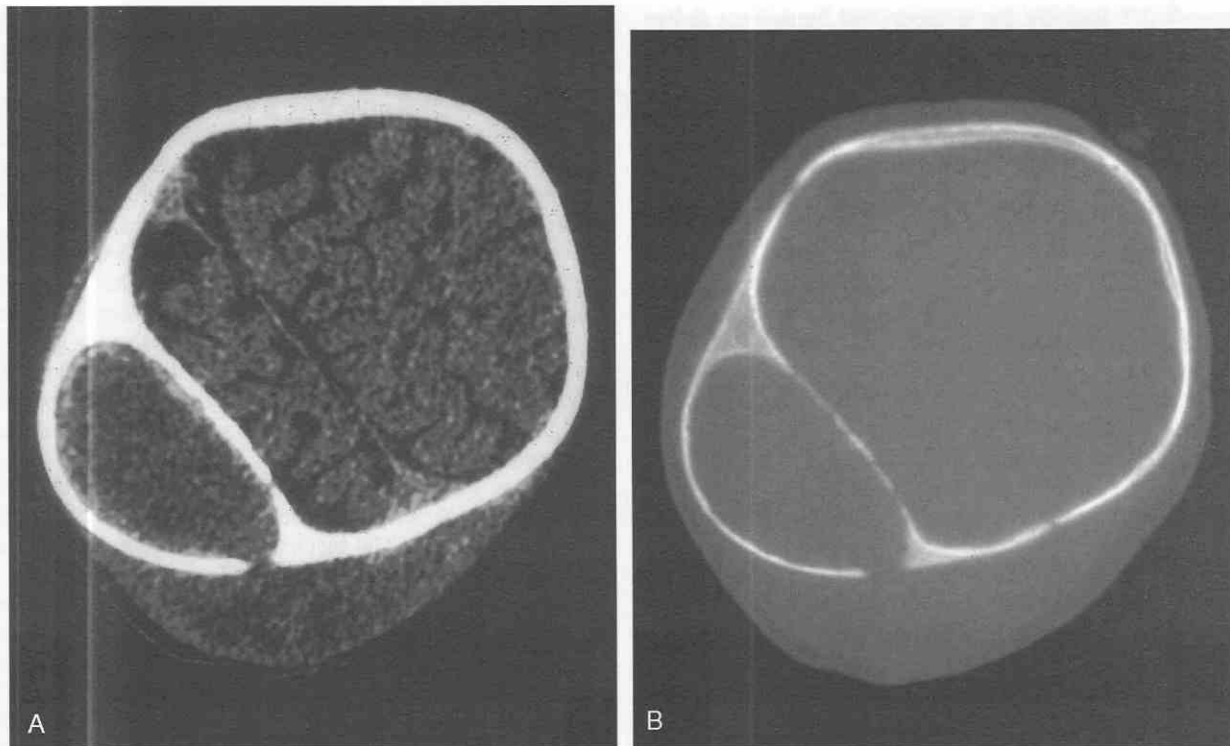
A and B, Cephalhematoma. CT scans with soft tissue and bone windows show partially ossified cephalhematoma overlying the right parietal bone. Note remodeling of the underlying parietal bone. Soft tissue swelling is present, overlying and posterior to the cephalhematoma.
